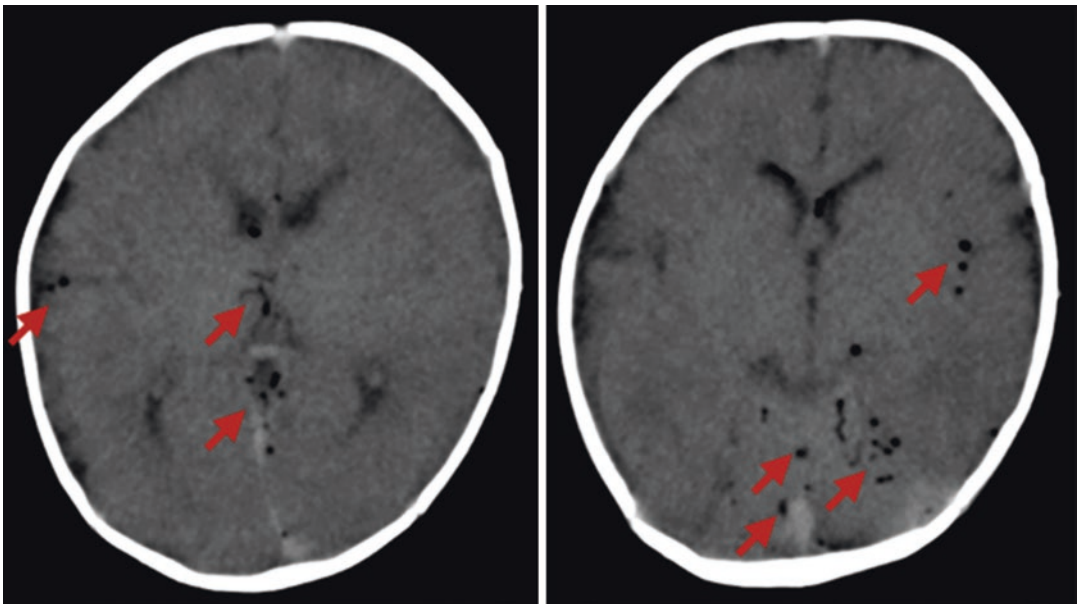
Intravascular gas (arrows) found in computed tomography images obtained immediately after death. The patient was subjected to resuscitation efforts, which may have caused these gas accumulations
